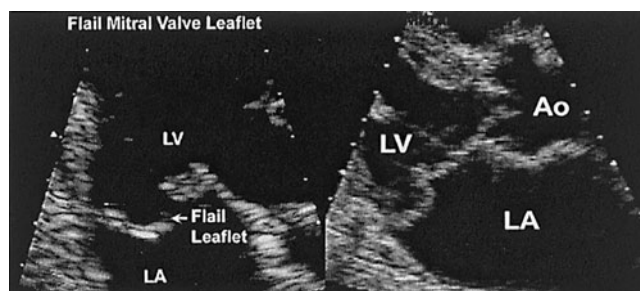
Examples of morphologic examination of organic mitral regurgitation in transthoracic echocardiography. (Left) The patient has a flail segment of the posterior leaflet with marked gap between the anterior and posterior leaflets during systole and the tip of the posterior leaflet in the left atrium. (Right) Simple mitral valve prolapse (or billowing mitral valve) shows posterior movement of the leaflet in the left atrium but no gap between the leaflets, and the tip of the posterior leaflet remains in the left ventricle in systole. Ao = aorta; LV = left ventricle; LA = left atrium; MVP = mitral valve prolapse.
